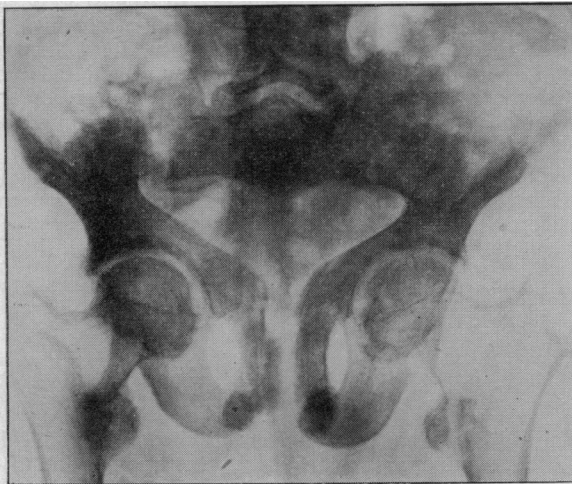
X-ray after three months of vitamin-D therapy showing callus formation at site of fractures.
